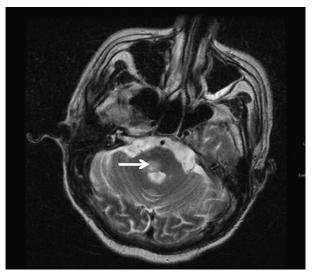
T2-weighted brain magnetic resonance imaging scan discloses a hyperintense lesion in the right side brain-stem (arrow).
